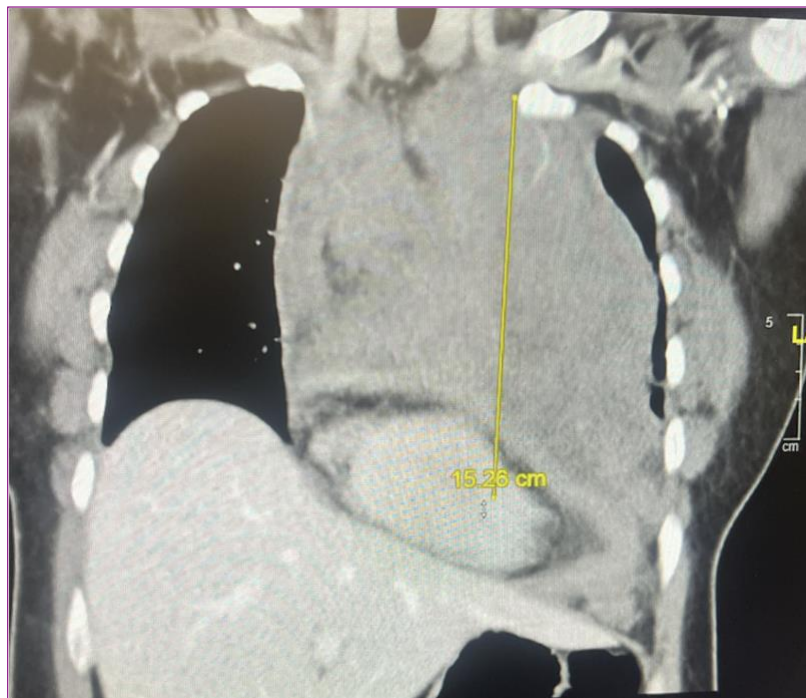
Computed Tomography Scan displaying a large (15.28 cm) mass in the mediastinum.
